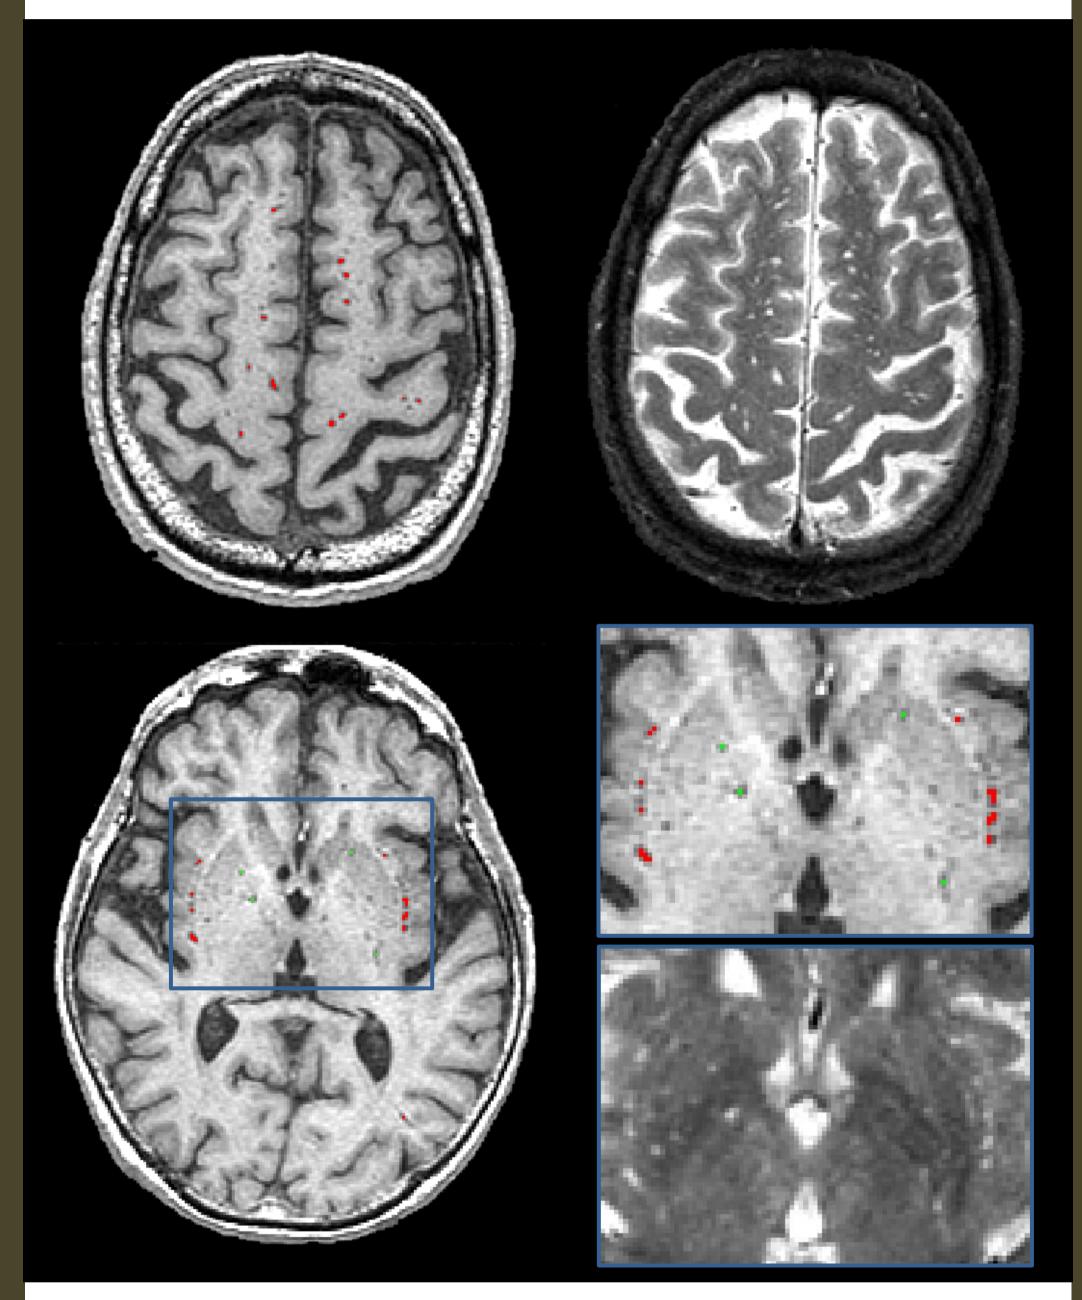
Virchow-Robin space segmentation (white matter VRS=red, basal ganglia VRS=green) overlaid on an axial T1 weighted MRI
